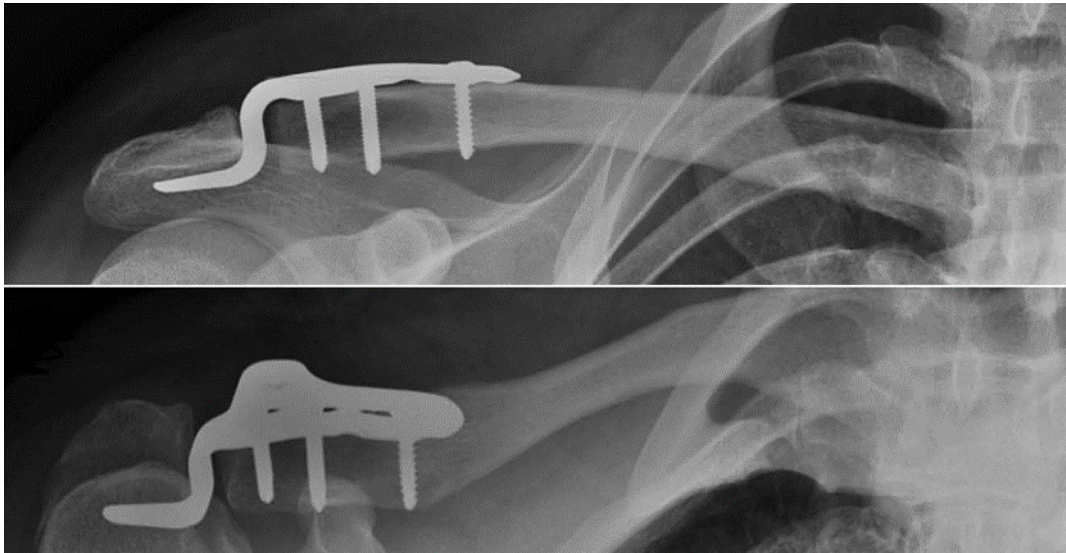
Radiographs consisting of two antero-posterior images, including one with 35–40° of caudal tilt of beams to assess the position of the hook plate and screws
